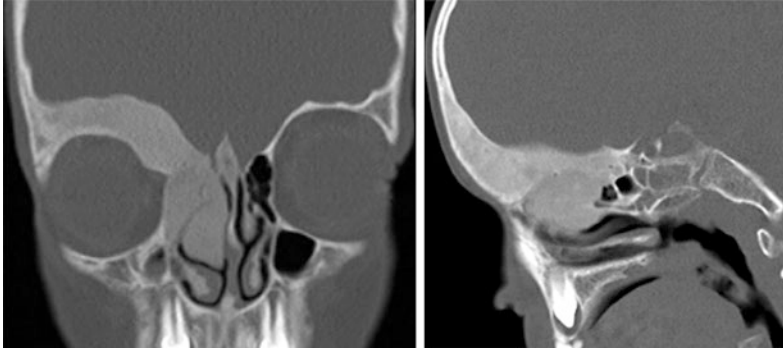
A 6 years old boy with fibrous dysplasia. a–b Coronal and sagittal CT images (bone window) reveal an expansile bone lesion with typical ground glass appearance involving the right orbital roof and right ethmoid bones. There is encroachment on the orbital cavity
